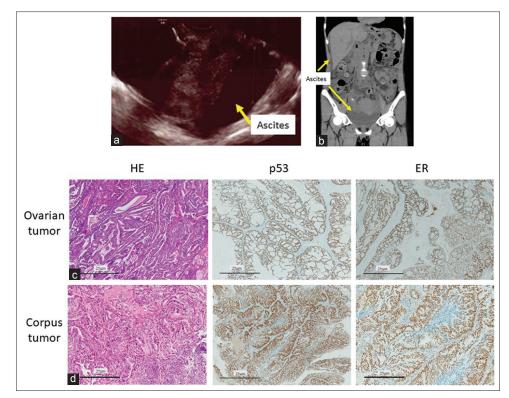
Findings of imaging tests after laparoscopy and pathological findings of tumor. (a and b) Imaging test findings; ultrasound examination (a) and computed tomography (b). (c and d) Pathological findings of tumor of ovary (c) and corpus (d); ×40. Left: HE, Middle: p53, Right: ER
